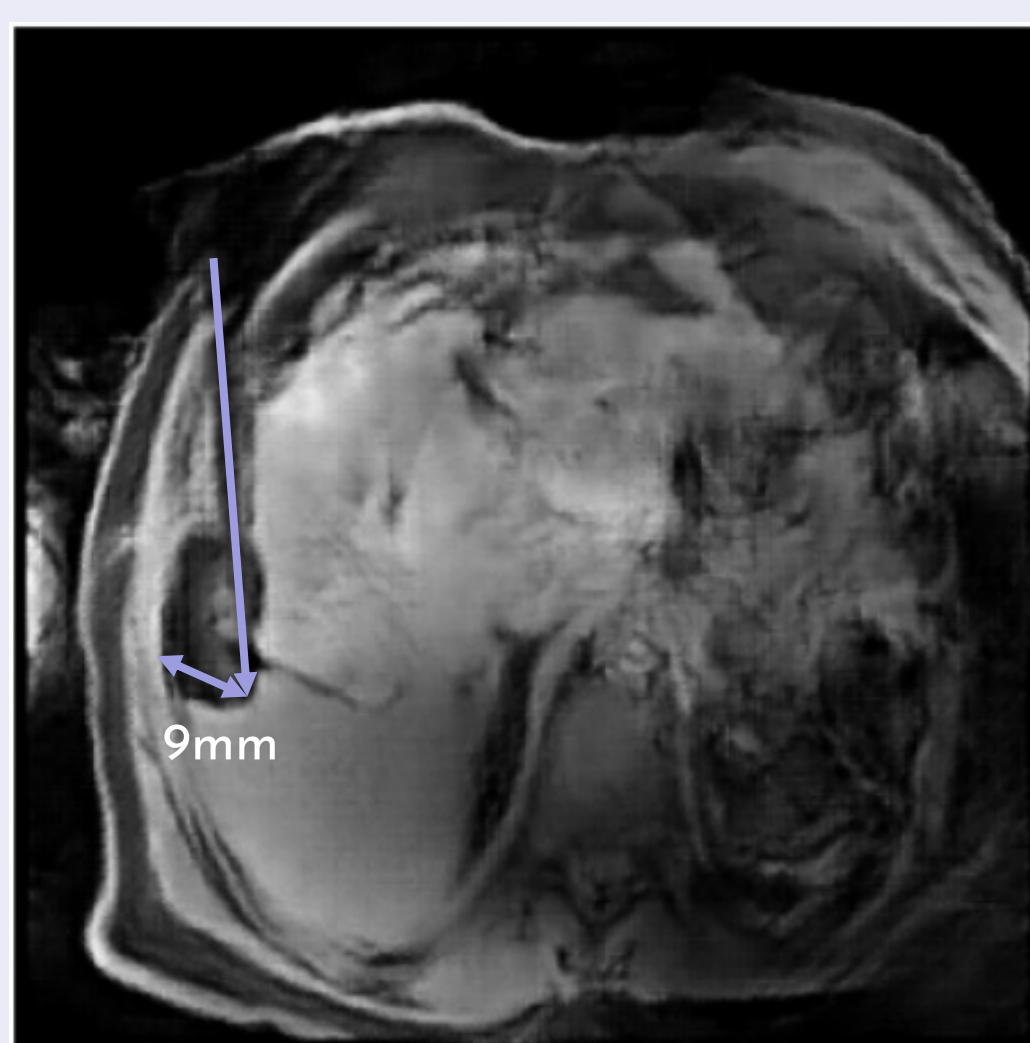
Needle Artifact from intraoperative MRI scan of percutaneous liver biopsy.
